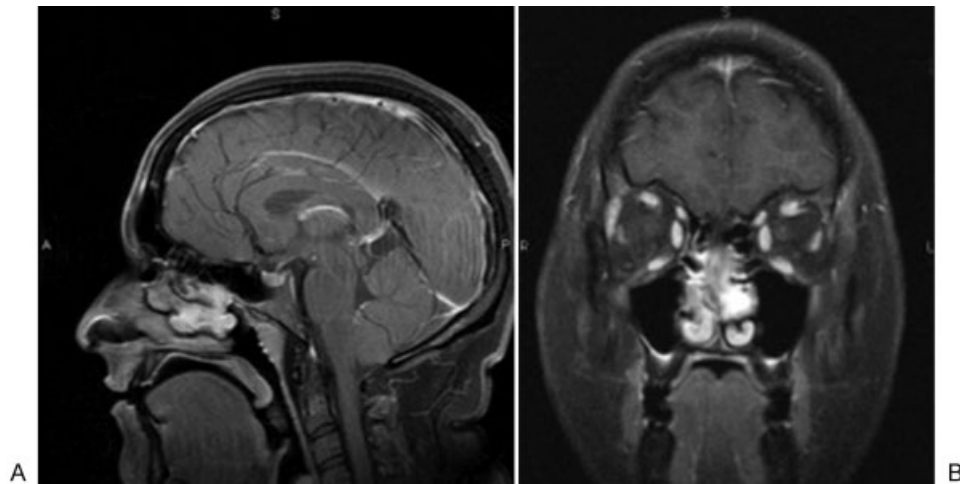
Preoperative (A) sagittal and (B) coronal T1-weighted postcontrast magnetic resonance imaging demonstrating a $2.8 \times 2.2 \times 1$ cm enhancing soft tissue lesion in the left nasal cavity located medial and inferior to the middle turbinate.
